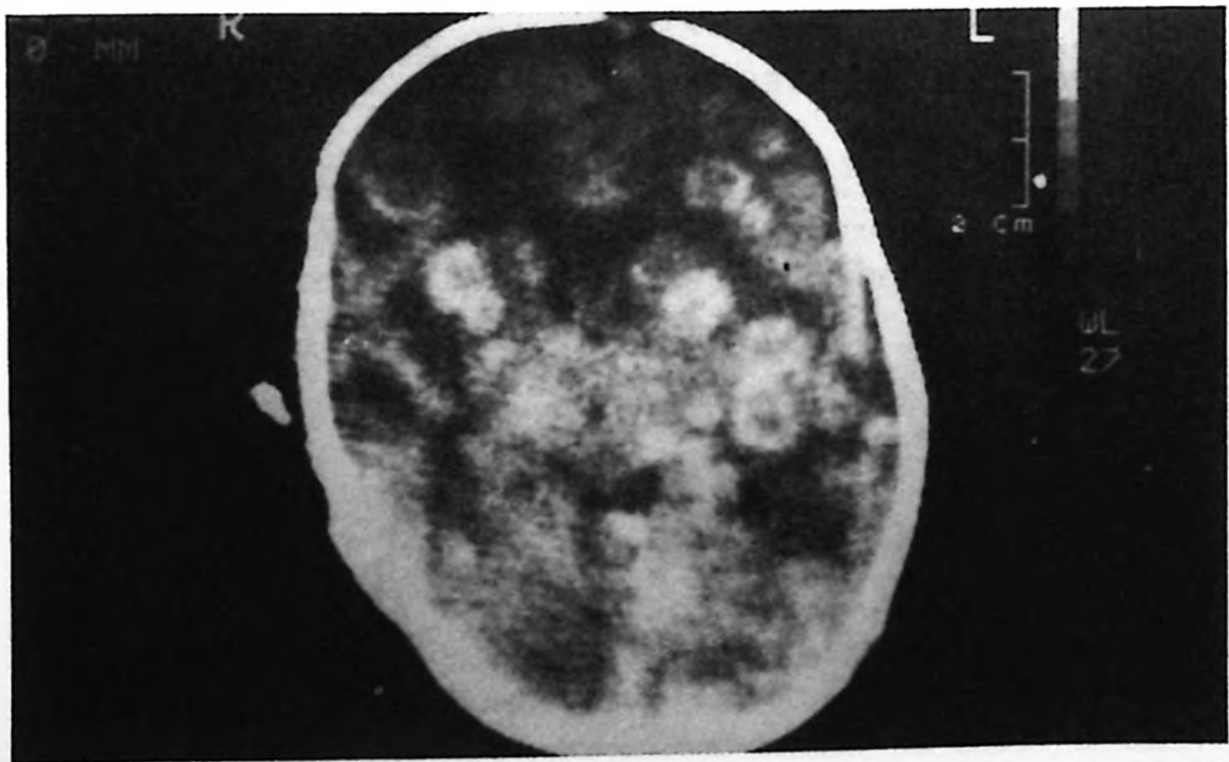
Initial contrast-enhanced computed tomography (CECT) scan showing multiple nodular lesions of different sizes with good enhancement (Case 1).
